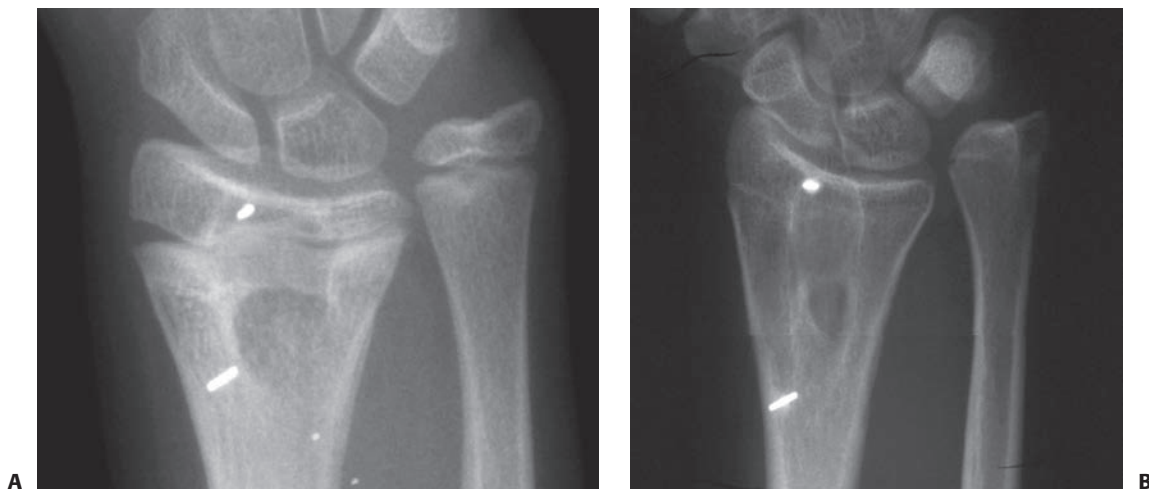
Fat used as an interposition material in partial physeal arrest resection can persist and hypertrophy during longitudinal growth. A: Radiograph appearance after traumatic distal radial physeal arrest resection. B: Appearance 5 years later. Longitudinal growth between the metallic markers is obvious. The fat-filled cavity created at physeal arrest resection has persisted and elongated with distal radial growth.
